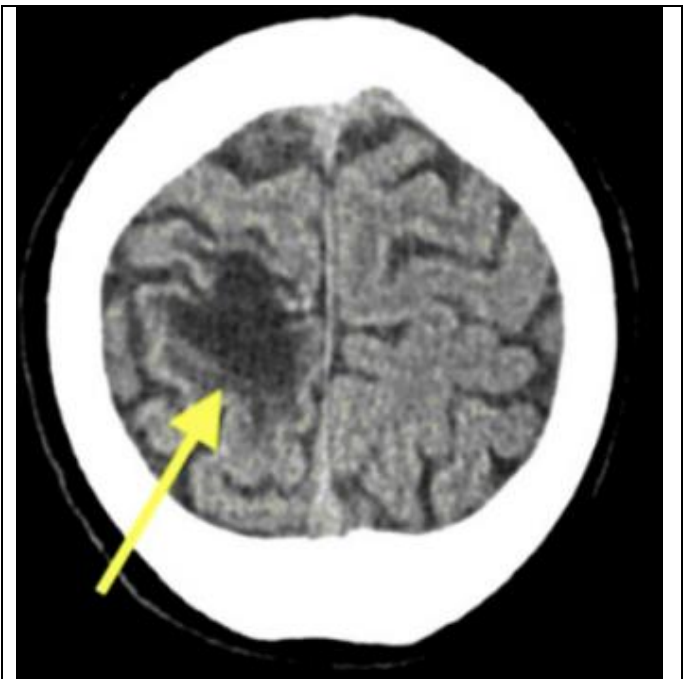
A non-contrast axial CT scan of the head shows a calvarial malformation slightly above the right frontal convexity region, indicated by yellow arrows.
